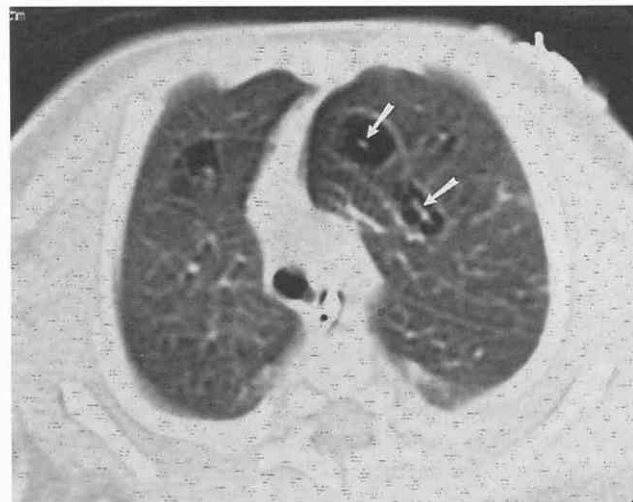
Persistent pulmonary interstitial emphysema in a 9-day-old girl. CT scan shows areas of lucency with central nodular and linear opacities (interstitial vascular structures) (arrows), documenting that the abnormal gas collection is within the interstitial space. (From Donnelly LF, Frush DP: Localized lucent chest lesions in neonates: Causes and differentiation. *AJR Am J Roentgenol* 172:1651, 1999.)
